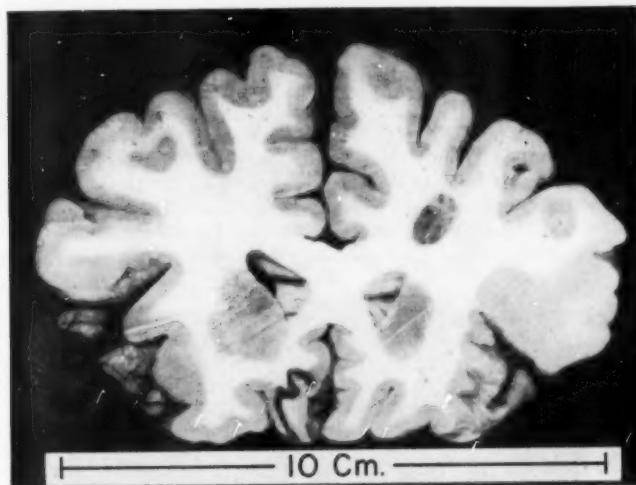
(Case 4).—Ultrasonic necrosis in the centrum ovale on the right side of the picture. This section through the beam axis is directed about 15 degrees posteriorly. The center of the necrosis and the anterior tip of the ventricle are approximately in the same vertical plane. Autopsy 19 days after irradiation.
